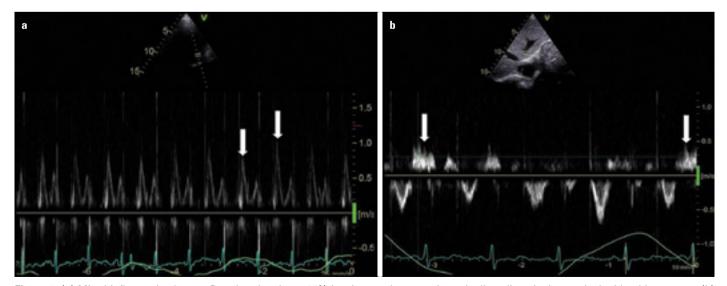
(a) Mitral inflow pulsed-wave Doppler showing a 25% inspiratory decrease in early diastolic velocity, marked with white arrows. (b) Expiratory diastolic flow reversal was seen in dilated hepatic veins, marked with white arrows (light green tracing previously correlates to simultaneous respirometer; downward deflection marks the beginning of expiration)
